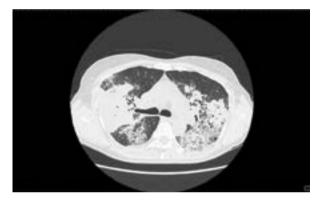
Computed tomography chest angiography showing interstitial consolidations in the upper zones of both lungs
